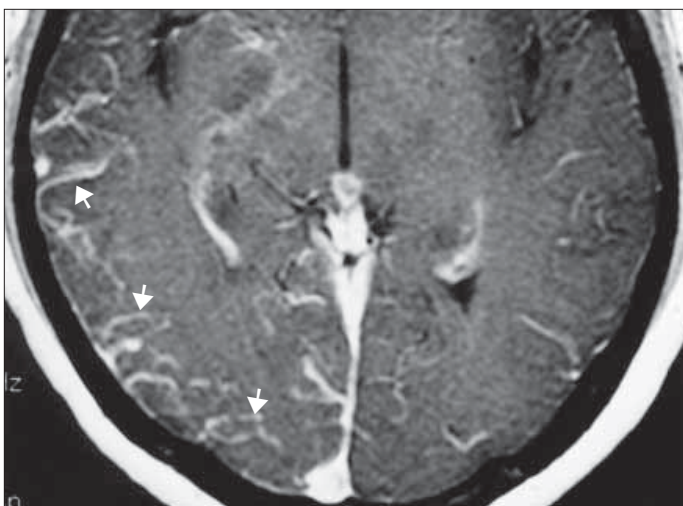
Axial postinfusion T1-weighted MR image shows venous collaterals (arrows) in the right occipital lobe.
